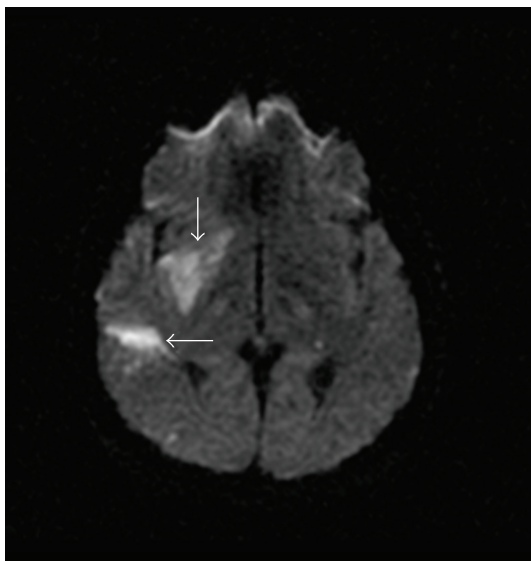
MRI of brain shows infarct in right putamen and temporal lobe (arrows).
